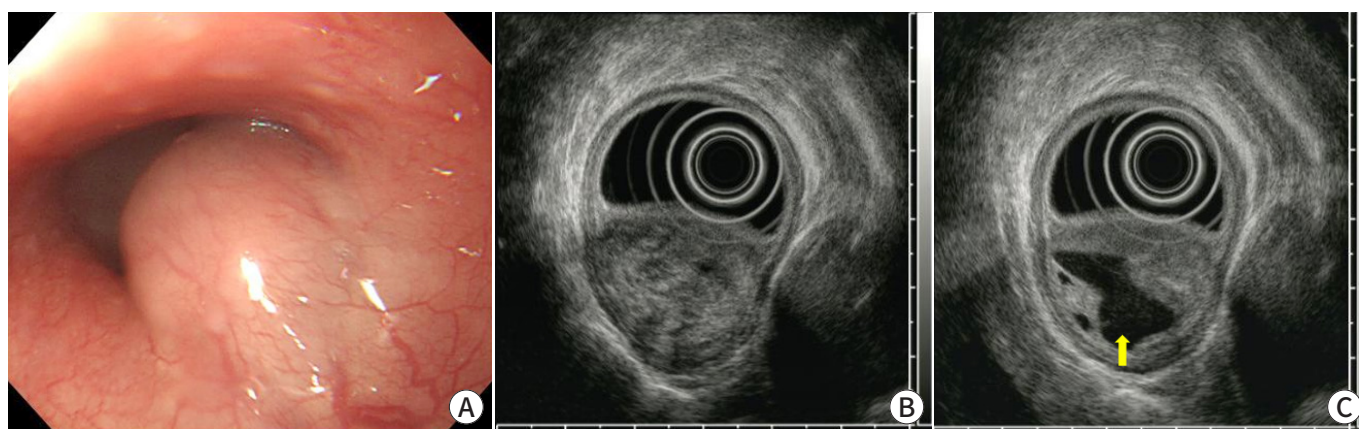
Endoscopic and endosonographic findings. (A) A subepithelial tumor, measuring 3 cm, without surface erosion or ulceration is evident in the lower esophagus. (B, C) Endoscopic ultrasonography reveals a heterogeneously hypoechoic lesion with cystic changes (arrow) in the proper muscle layer.
